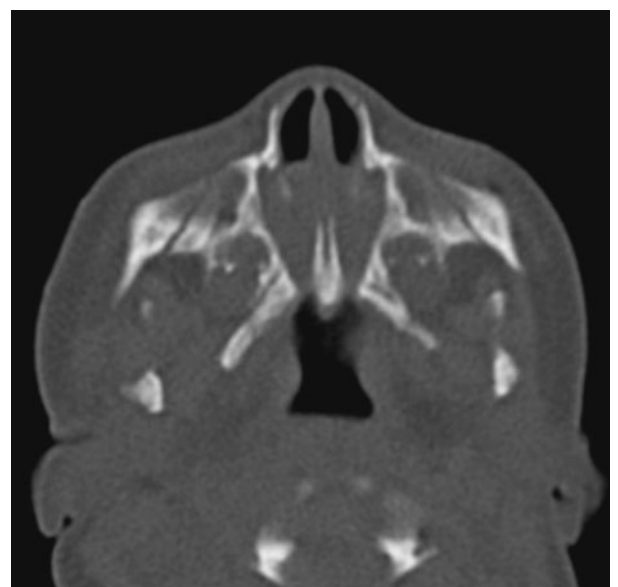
Computed tomography (CT) choanal atresia. CT is the best modality for assessing the bony narrowing of the choanae. In this case there is severe bilateral narrowing of the posterior nasal cavity in a patient with bilateral choanal atresia.
